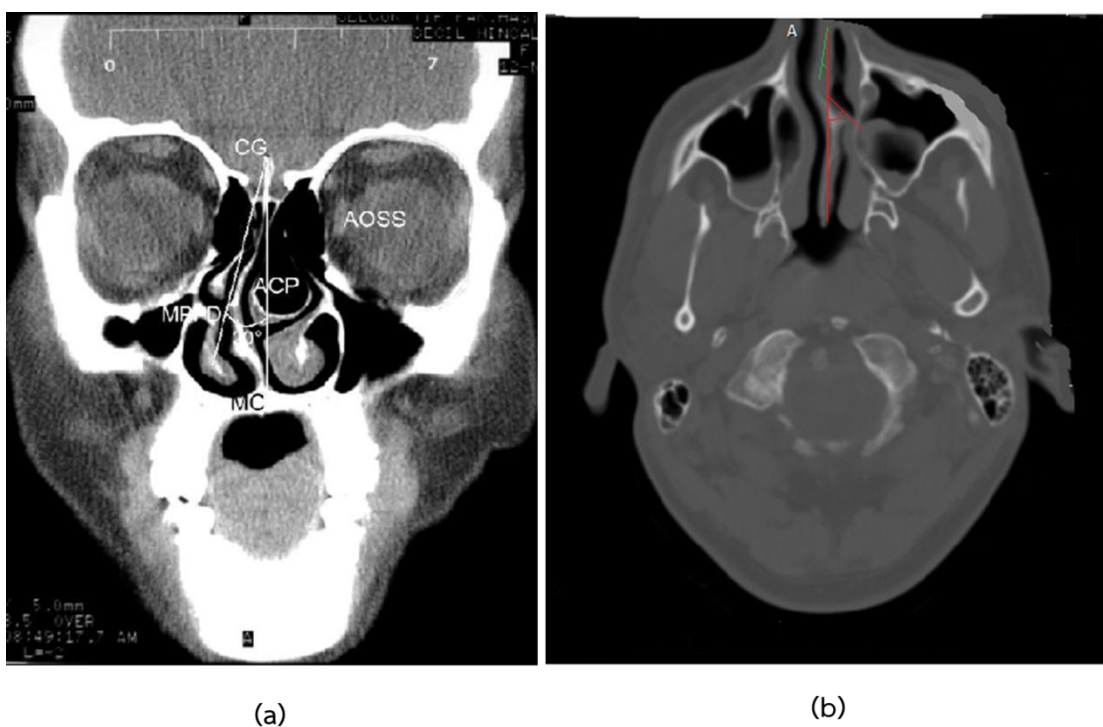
(a) presents Bahar K 's method measuring the deviation angle in coronal CT images: CG, crista galli; AOSS, area of orbit on the same site; ACP, area of concha pneumatization; MPPD, most prominent point of the deviation; MC, maxillary crest. Calculation of deviation angle according to the angle between CG and MPPD. (b) presents Alireza M 's method measuring the deviation angle of the center line in axial CT images:  $0 < \text{normal} < 5$ ;  $5 < \text{mild} < 10$ ;  $10 < \text{moderate} < 20$ ; and  $\text{severe} > 20$  (figure was modified from Bahar K. and Alireza M. [53, 54])
